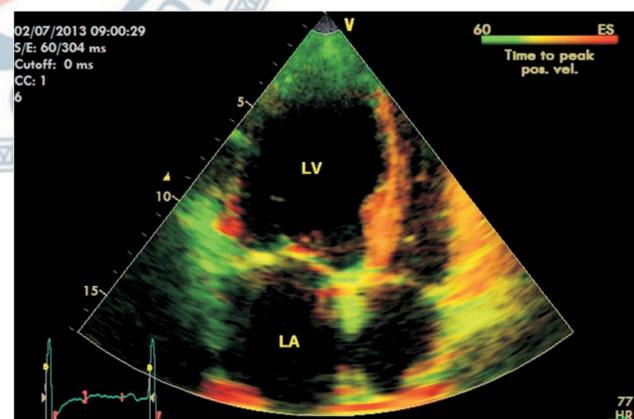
Tissue synchronization imaging (TSI) image on apical four-chamber view showing the presence of septal wall delay in a heart failure patient with normal QRS duration. TSI was derived from 2D tissue Doppler imaging (TDI) images and automatically color-coded time to peak myocardial velocity (Ts) with reference to the QRS signal. The TSI algorithm color coding ranges from green (earliest) through yellow and orange to red (latest) within this interval. Ts of septal wall of LV more delayed when compared with apical wall.
